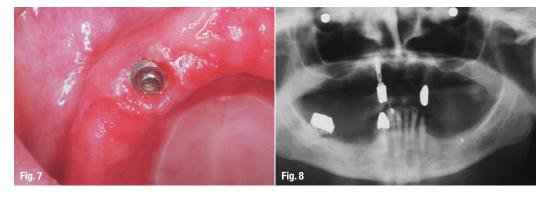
\_Even after removal of the secondary crown, healthy periimplantary conditions are found. Fig. 8 X-ray (OPT) 1994.
